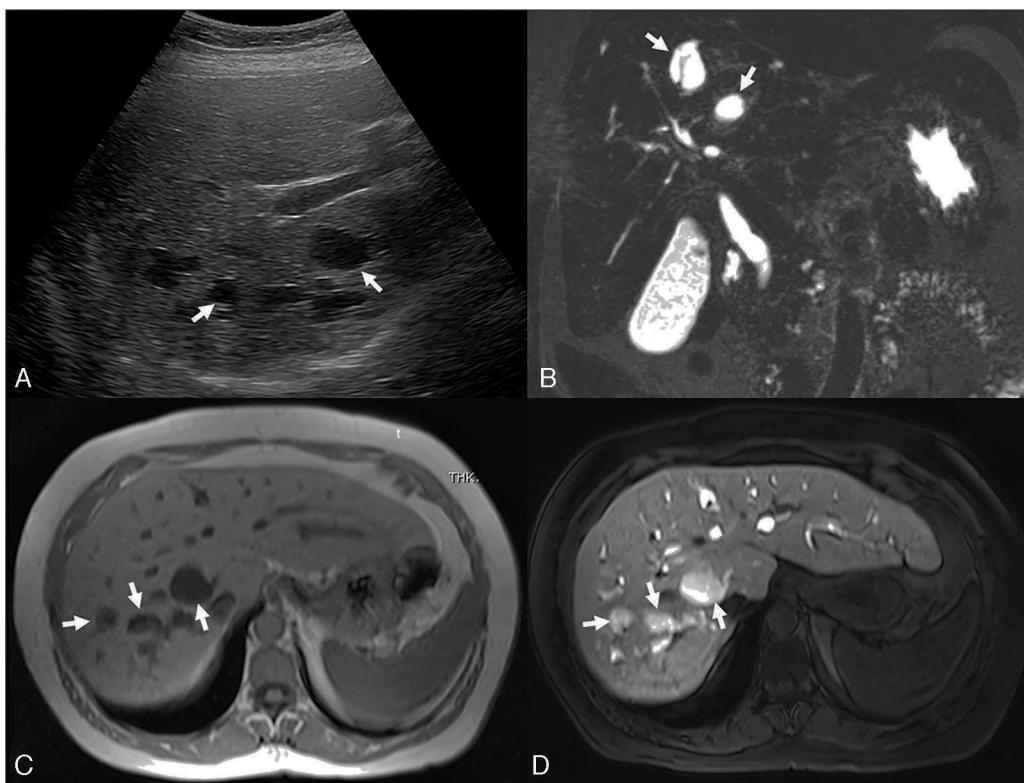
Ultrasound image (A) demonstrates multiple intrahepatic cysts (arrows). Coronal conventional T2-weighted MR cholangiography (B) and axial pre-contrast T1-weighted MR image (C) confirm the finding of multiple liver cysts in close relation to the biliary tree (arrows), some of them with the central dot sign (B). Late hepatobiliary phase of contrast-enhanced MR cholangiography using gadoxetic acid (D) demonstrates filling of cysts by contrast agent (arrows), proving their communication with the biliary tree and adding complementary information supportive of a diagnosis of Caroli disease.
